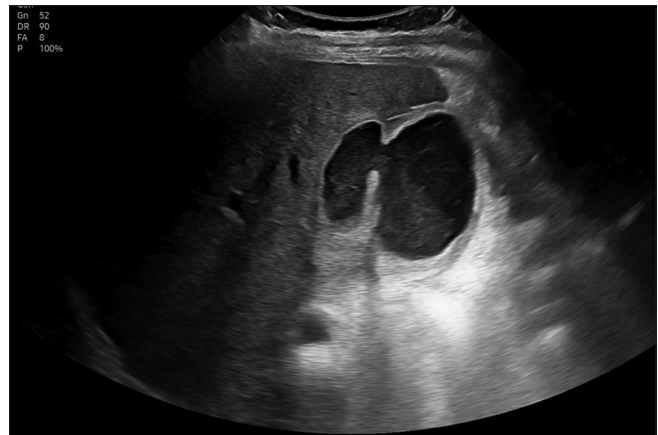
Grayscale ultrasound image of the gallbladder
